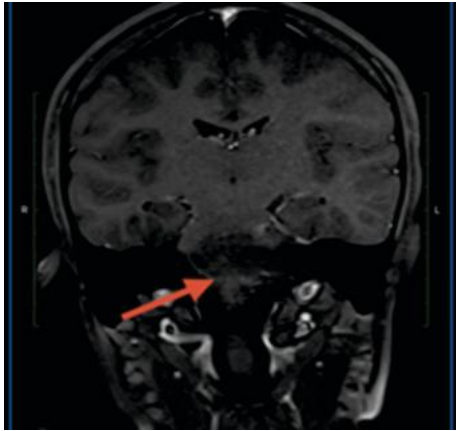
MRI brain (coronal view) demonstrating lesion centered in pons with exophytic extension.
